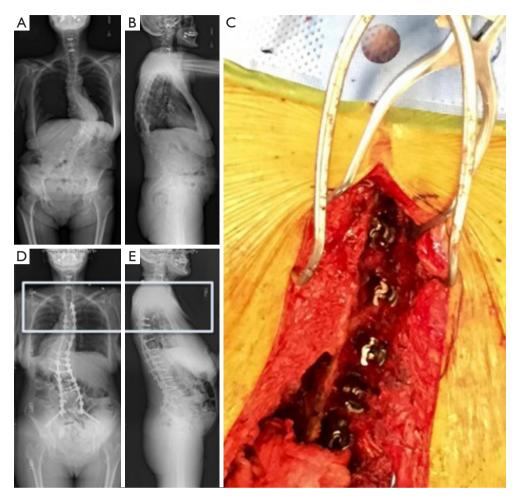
Intraoperative imaging of the Soft Landing technique. (A) Preoperative AP and (B) lateral standing radiographs of a patient that will undergo the Soft Landing technique. (C) Intraoperative image of the Soft Landing technique. On the right side, 3 supra laminar hooks were positioned, while the left side was maintained intact. (D) Postoperative AP and (E) lateral standing radiographs of a patient that underwent the Soft Landing technique with boxed area representing the location of the image taken in (C). Radiographs were taken 6 months postoperatively, with PJK measuring 6.7° at that time. PJK, proximal junctional kyphosis; AP, anteroposterior.
